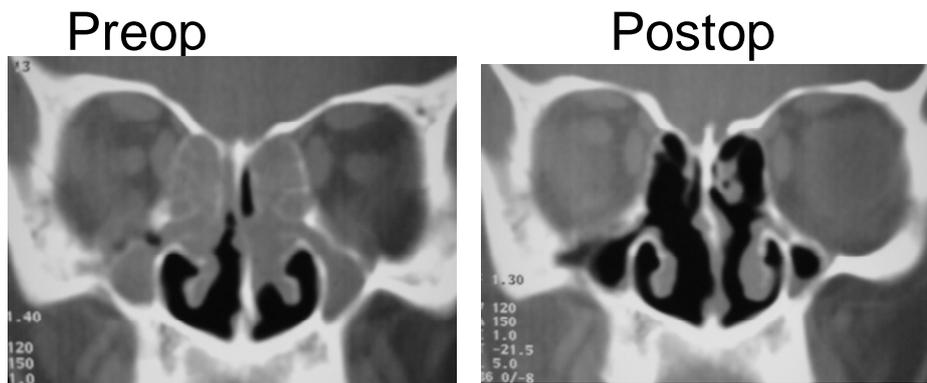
(A):Coronal CT (Anterior section)showing partial resection of the inferior border of MT with anterior ethmoidectomy and clearance of infection.
